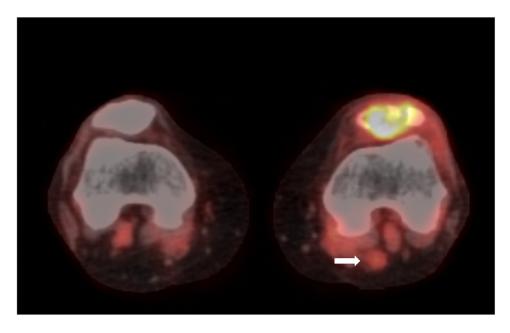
CT-PET demonstrating a patellar lesion with hypermetabolic FDG uptake to maximal SUV of 10.6. Also noted is an 8 mm soft tissue density within the popliteal fossa with increased FDG uptake to 2.6 SUV representing lymph node involvement (white arrow).
